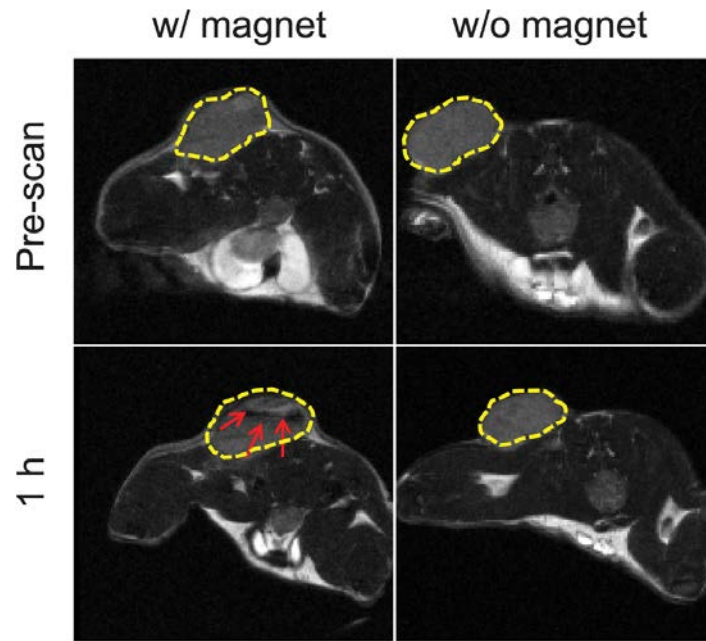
T2-weighted MR images taken prior to and 1 h after the injection of ZW800 loaded IONP-DTMs. Black areas (highlighted by red arrows) were observed in tumors where a magnet was attached to the tumor skin. By contrast, no signal change was observed if no magnet was applied.
